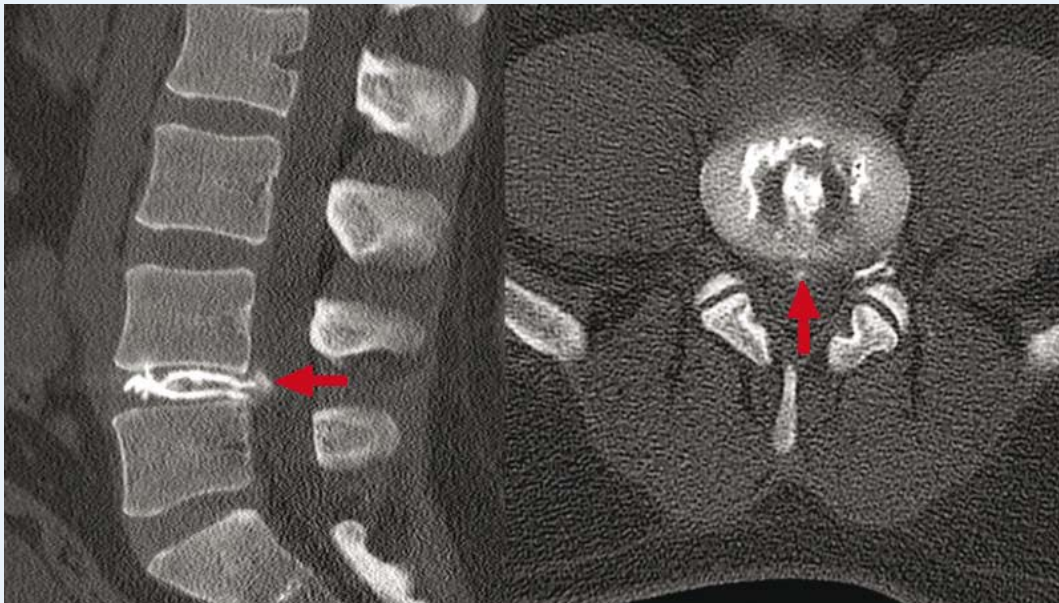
Dallas discogram, fifth degree annular tear. In axial CT profile and reformatted sagittal image, it can be seen that the contrast agent injected to the central region of intervertebral disc spread to the out of the disc by passing through the tear located in outer annular layer.
